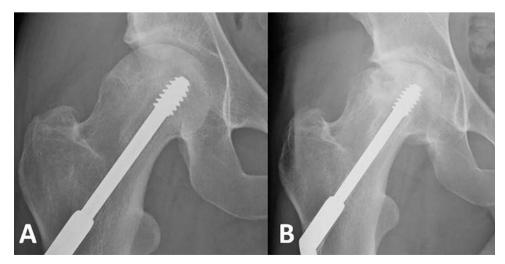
X-ray of patient with unilateral osteonecrosis of femoral head secondary to femoral neck fracture. A: After internal fixation of femoral neck fracture; B: At 5 years after internal fixation.
